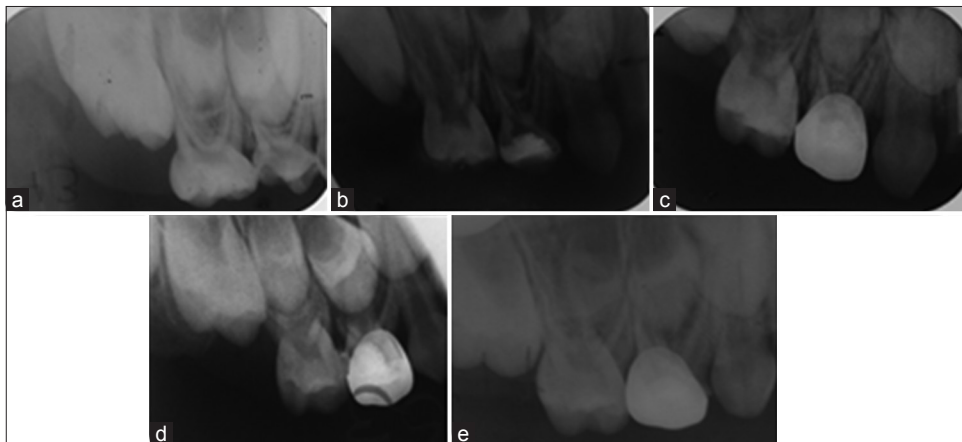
54 treated with modified 3Mix-MP paste after lesion sterilization and tissue repair therapy (radiographic success). (a) Preoperative (b)postoperative, (c) After 6months (d) after 12 months (e) After 18 months
